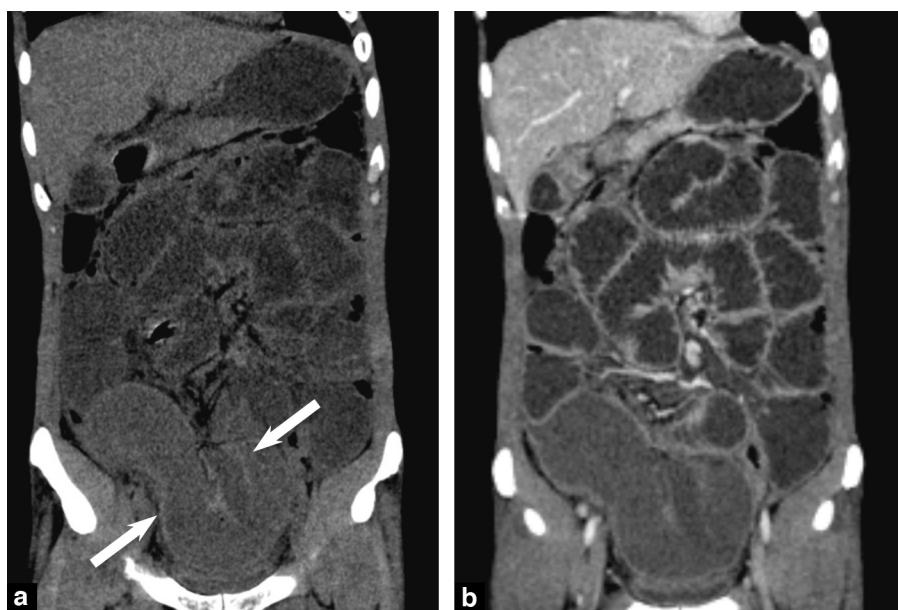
Coronal CT image without (a) and with injection (b) of a closed loop obstruction on adhesions with intestinal ischemia. Spontaneous hyperdensity of the walls of the incarcerated loops (arrow in a) and lack of enhancement after injection (b). Note the hyperdense sero-hematic contents of the ischemic loop (a).
